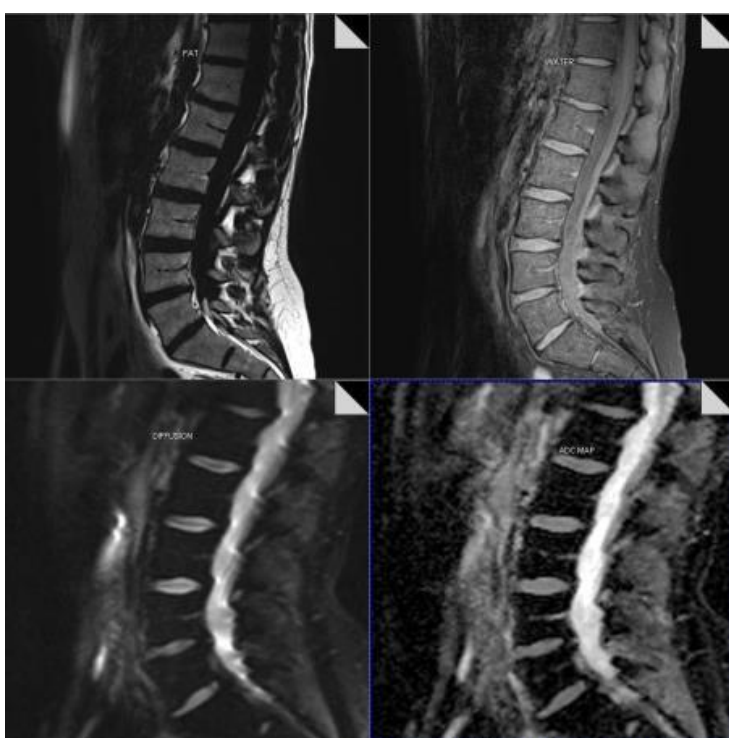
Mid-sagittal MRI of the lumbosacral spine of the author showing (clockwise from upper left) Fat only, Water only, Diffusion and Apparent Diffusion Coefficient (ADC) map. The first two are Dixon sequences derived from In and Out of phase images, and the ADC map is derived from various diffused weighted b-values from 0 to 750 in three orthogonal planes.
